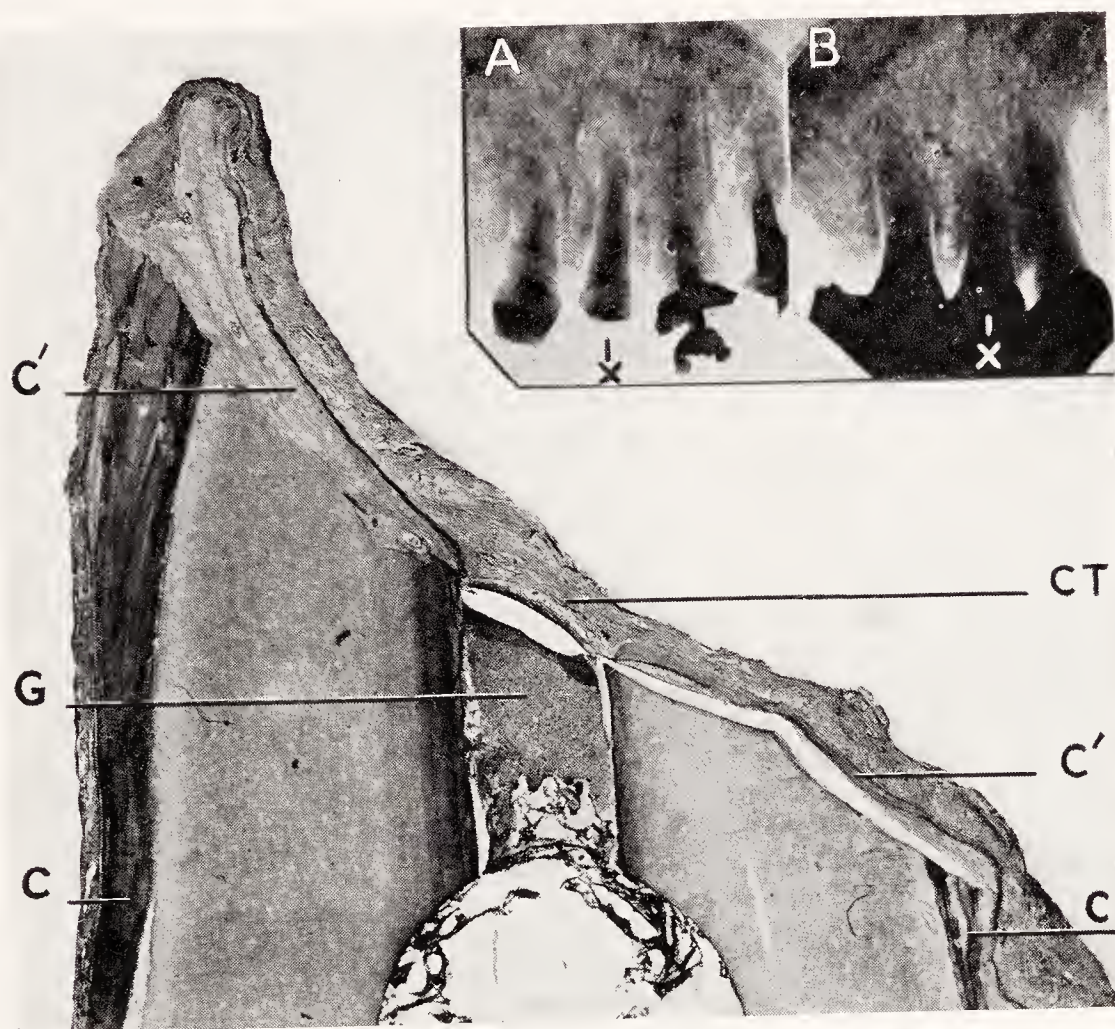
Tissue repair following root resection. *A*, radiograph of an upper second bicuspid with imperfect root canal filling and marked destruction of the periapical bone. This radiograph was taken in 1914, immediately before the root resection was performed. *B*, same tooth as it appeared in 1928. The area formerly occupied by the apex and the granuloma is entirely filled by bone. Bucco-lingual section through resected root end. Deposition of cementum and regeneration of a normal periodontal membrane on the resected surface. *G*, guttapercha root canal filling; *C*, original cementum on root surface; *C'*, cementum deposited on the resected root surface; *CT*, connective tissue capsule bridging the root filling material. (Coolidge, Jour. Am. Dent. Assn.)
